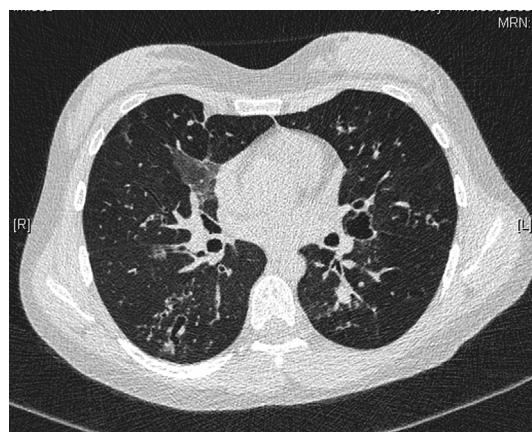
Chest CT of a patient with ABPA, showing proximal bronchiectasis, bronchial wall thickening, ground-glass attenuation, centrilobular nodules.
